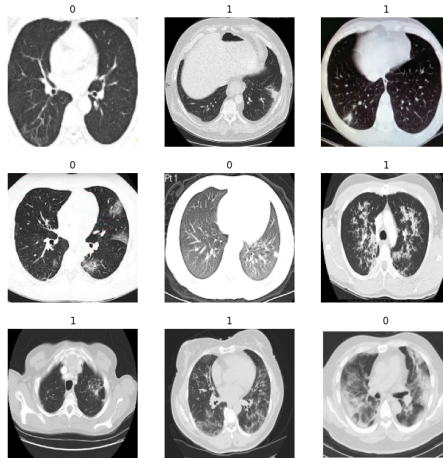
CT images preview
